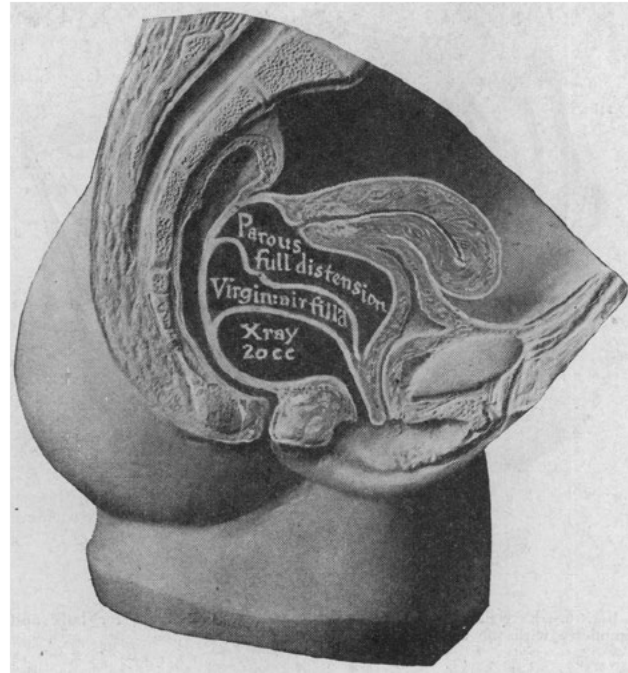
Capacity of moderately distended vagina, from the Kolbow x-rays in dorsal posture and the Dickinson averages of 116 cases taken on knee chest posture under atmospheric pressure.
